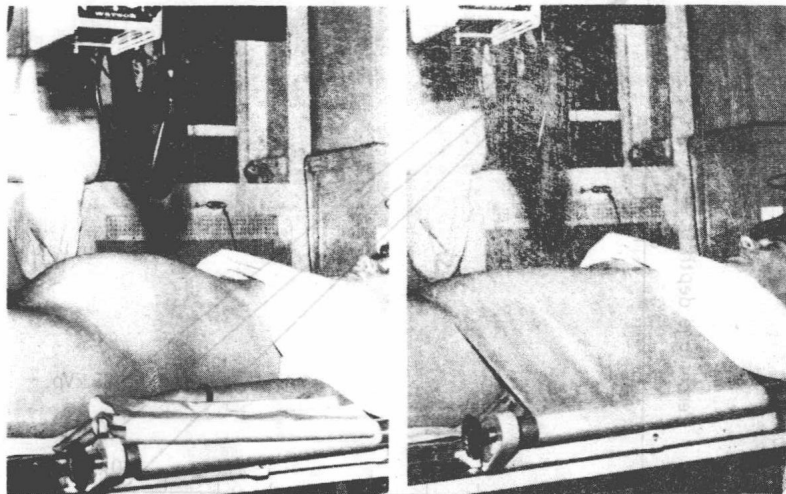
A pregnant woman lying supine on a radiography table, with and without a compression band. Note the significant reduction in maternal thickness with the compression band, which allows substantial reduction in the fetal dose
